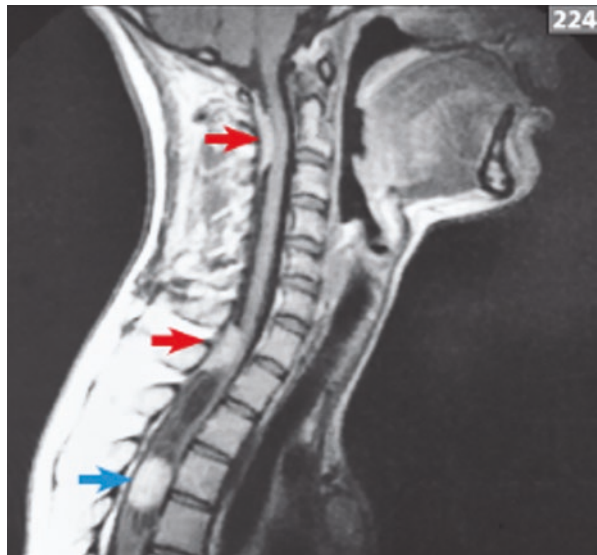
Spinal cord lesions in neurofibromatosis type 2. A sagittal T1-weighted MRI of the cervical and thoracic spinal cord with gadolinium enhancement, showing two enhanced extramedullary tumors, which are meningiomas (red arrows), and an enhanced intramedullary cervical cord astrocytoma (blue arrow) with a syrinx (beginning at T1)
